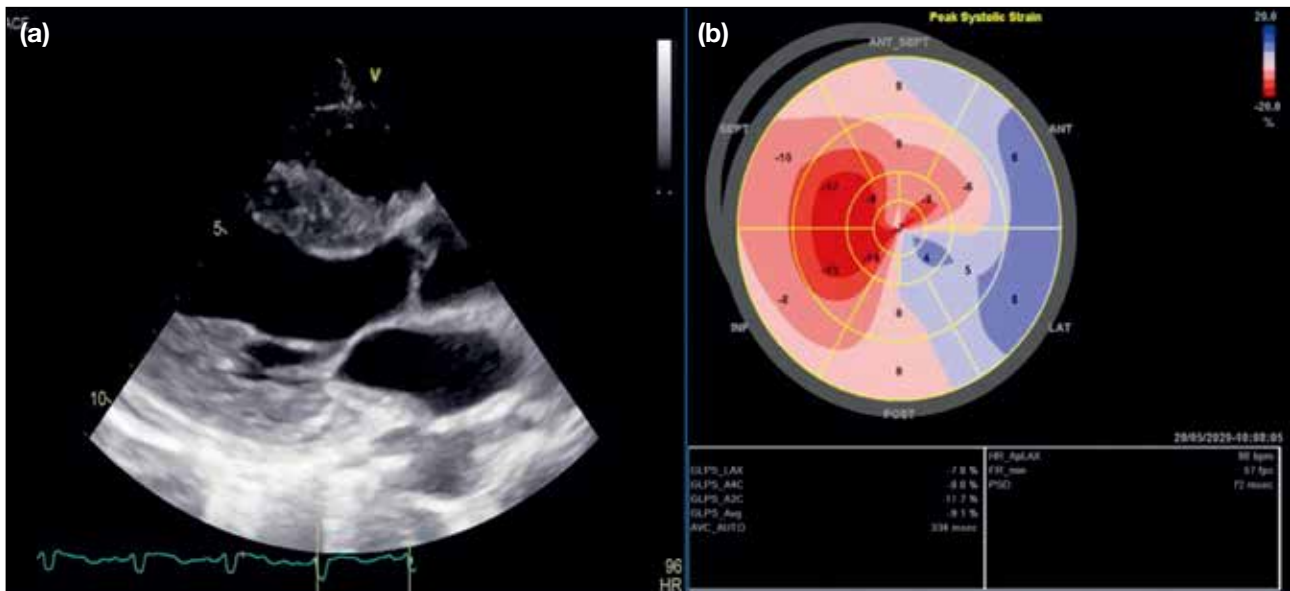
(a) Echocardiogram in parasternal long axis view showing marked increase in left ventricular wall thickness. (b) Strain image showing decreased global longitudinal strain with apical sparing.
